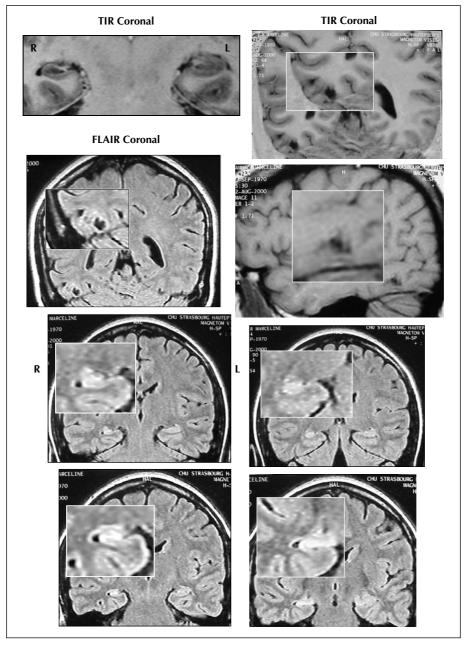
Structural neuroimaging MRI: Right hippocampal sclerosis and a right posterior post-traumatic scar.
